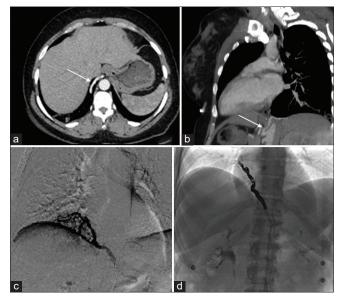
A 36-year-old female who presented with large volume hemoptysis. Axial arterial phase (a) and curved multiplanar (b) CT demonstrating an aberrant single vessel extending superiorly from below the diaphragm (arrows). (c) Digital subtraction angiography demonstrating an aberrant artery off the celiac trunk supplying the right lower lobe sequestration. (d) Post-coil embolization image demonstrating appropriate coil pack.
